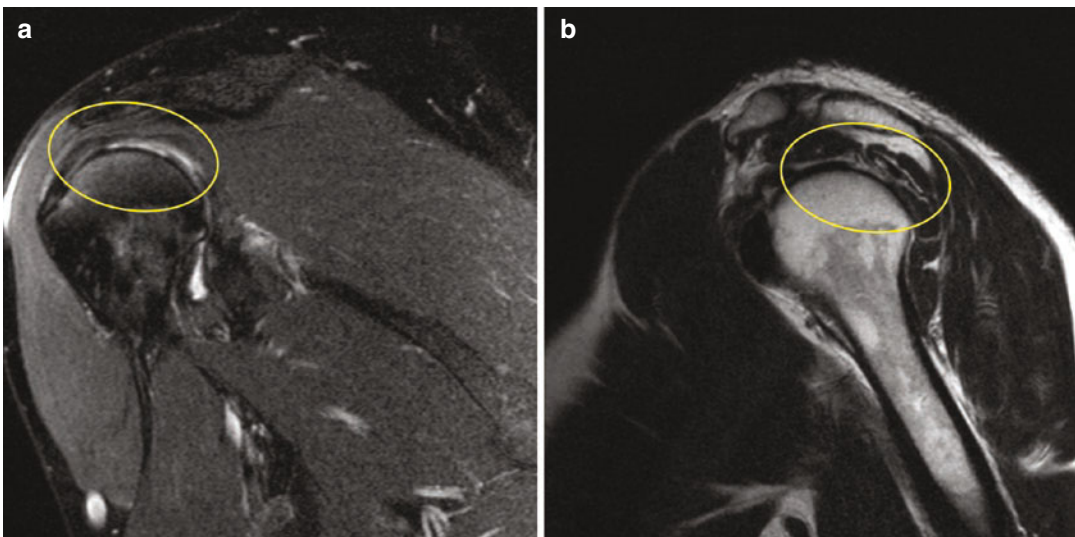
MRI images of posterosuperior cartilage lesion. (a) Coronal and (b) sagittal view
